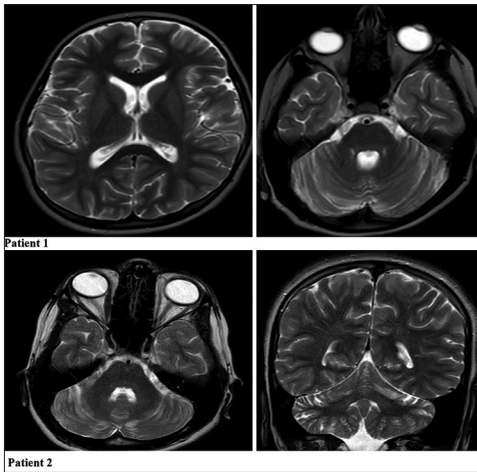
Cerebellar and mildly cortical atrophy are noticed in the brain MRI
